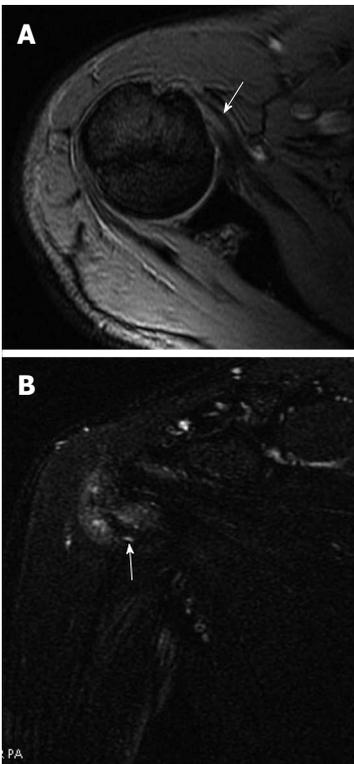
Subscapularis tendinosis. A: Axial gradient-recalled echo image showing focal high signal within the subscapularis tendon with fibres thickening (arrow); B: Anterior coronal oblique fat-sat T2-weighted image of the same patient showing high signal within the lower fibres of the subscapularis tendon (arrow).
